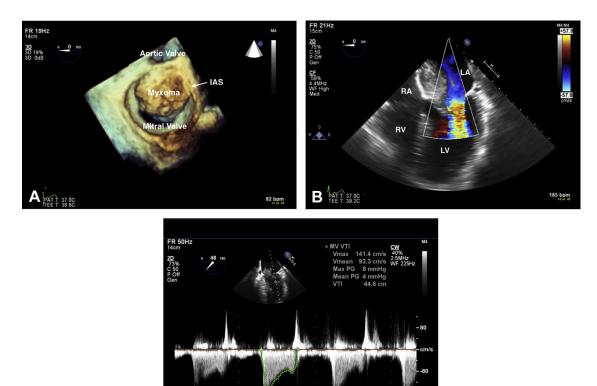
(A) Three-dimensional en-face view of the left atrium (LA) myxoma, as seen from the LA. (B) Midesophageal four-chamber view with color flow Doppler. The LA myxoma is seen partially obstructing the left ventricular (LV) inflow. (C) Continuous-wave Doppler across the mitral valve. *IAS*, Interatrial septum; *RA*, right atrium; *RV*, right ventricle.
